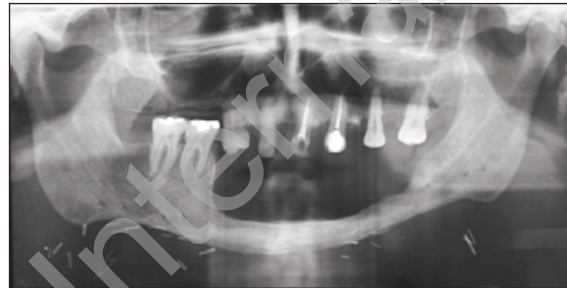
Orthopantomography pre-rehabilitation.
